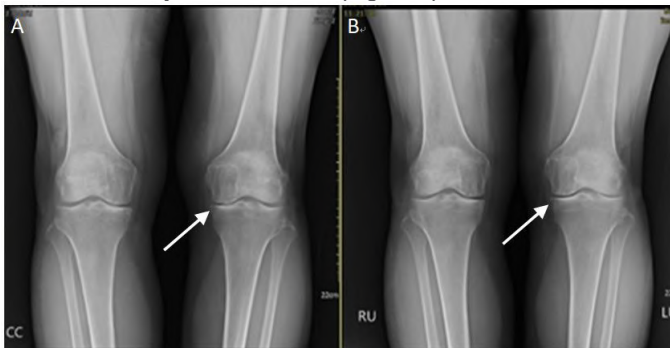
X-ray image before (A) and post (B) 6 months PCP treatment
